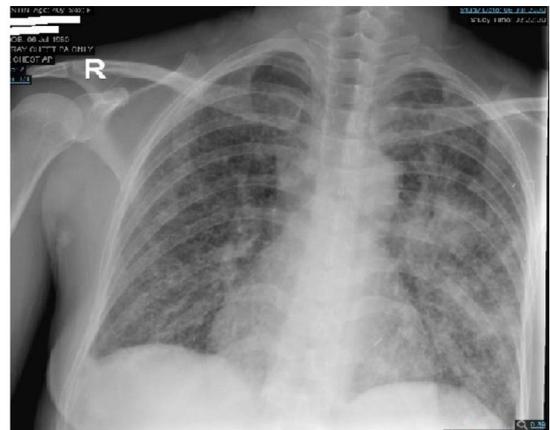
Chest X-ray showed bilateral diffuse alveolar and patchy opacities more prominent in left lung.
